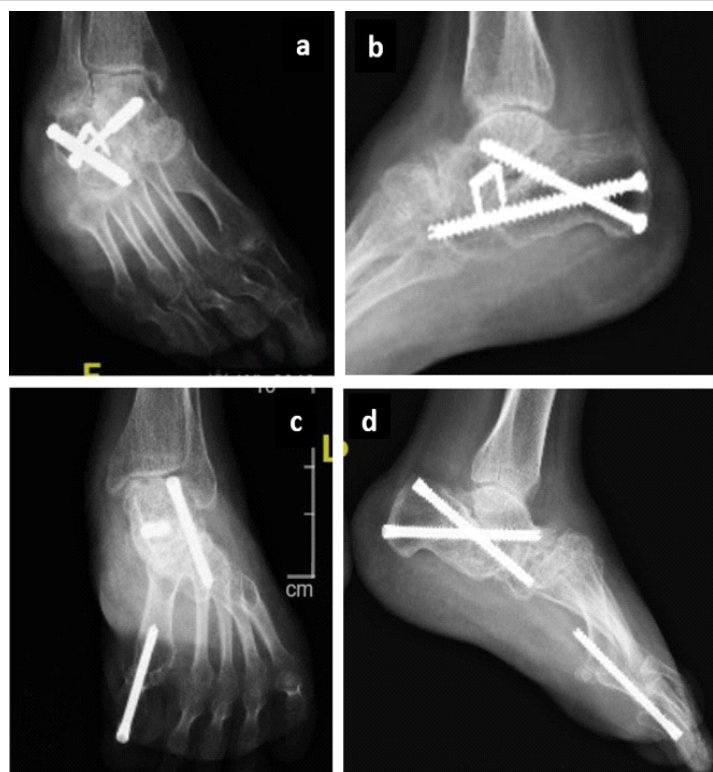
Follow-up radiographs (a) at 12 months of right foot showing complete subtalar arthrodesis with maintained alignment and no evidence of implant-related complications and (b) at 15 months of left foot (c and d) showing complete subtalar arthrodesis and with maintained alignment and corrected hallux varus with no evidence of implant-related complications.
